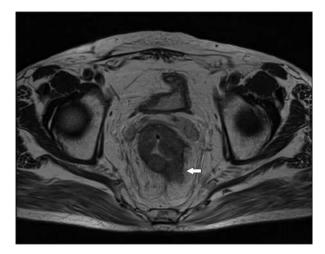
Axial T2-weighted MRI images show rectal tumor. Distance between the tumor and mesorectal fascia (MRF) is less than 1 mm (white arrow) representing a threatened MRF.
